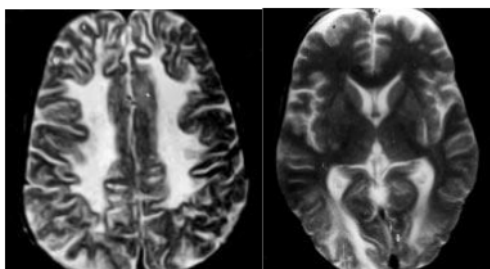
MRI of a patient with SSPE. The left display shows white matter demyelination diffuse and the right shows the hyperintensity of the occipital region.¹⁷
